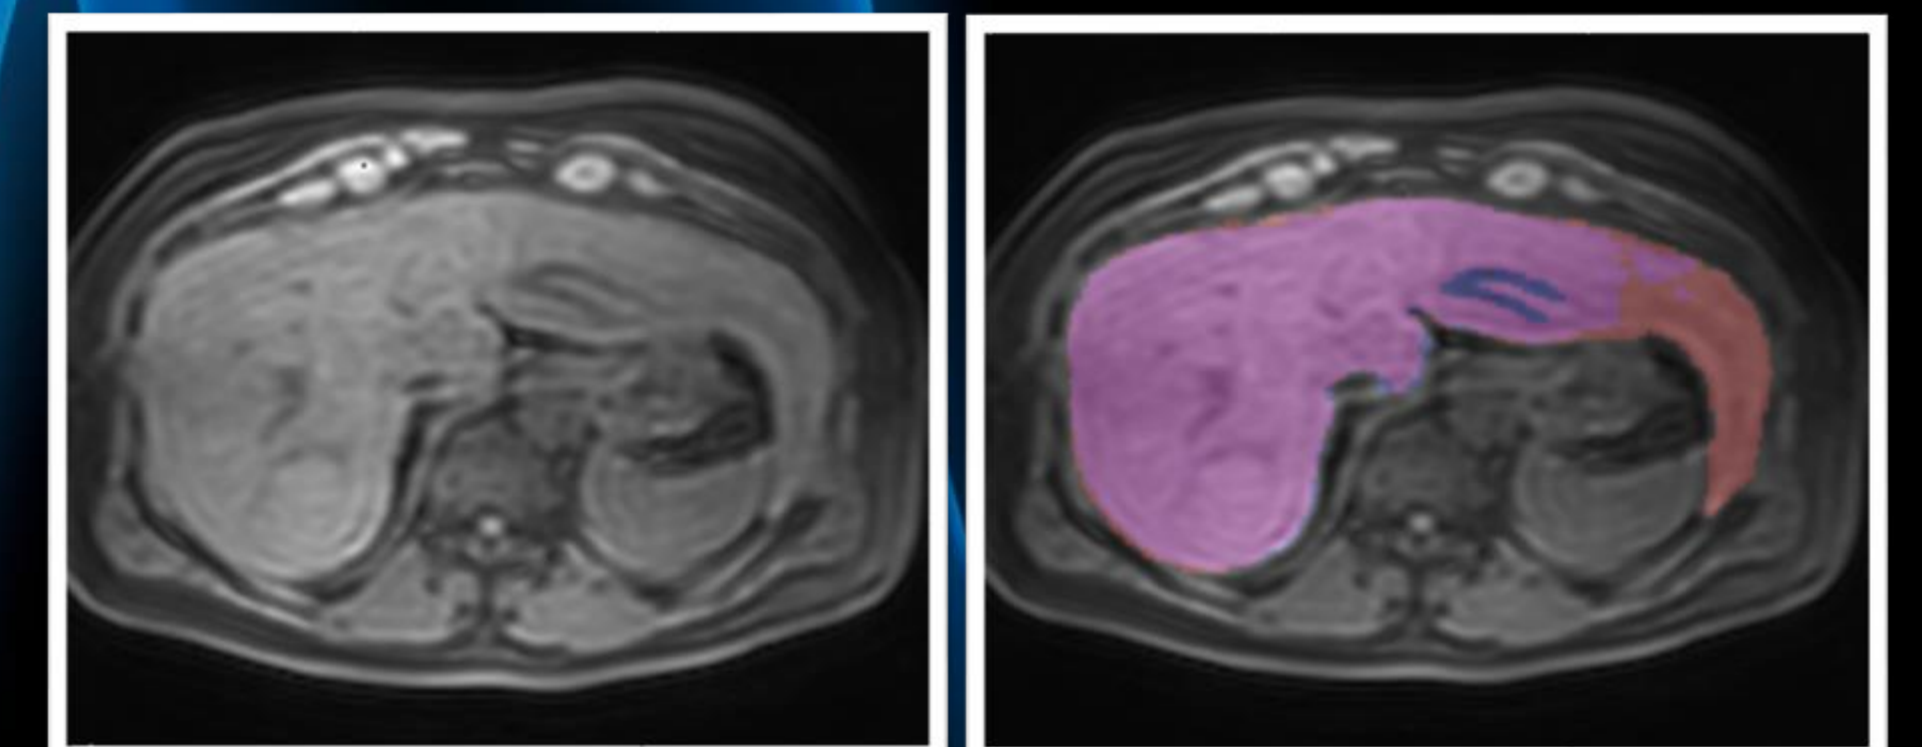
the two figures above show the unsegmented MRI scan on the left and the proposed liver volume segmentation from our model. Where purple is correct, red is under-segmentation and blue is over-segmentation. Notice how the proposed segmentation is missing most of the right part of the liver because of its unusual shape.
